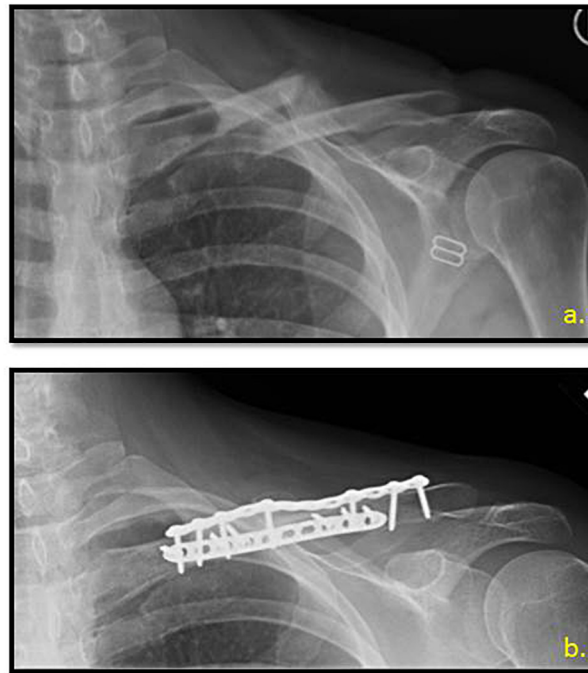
a.) Case 1 anterior-posterior (AP) radiograph demonstrating a displaced, midshaft clavicle fracture with overriding fracture components and callus formation. b.) Case 1 AP radiograph at 10 weeks postoperatively showing a well-aligned, healing midshaft clavicle fracture.
